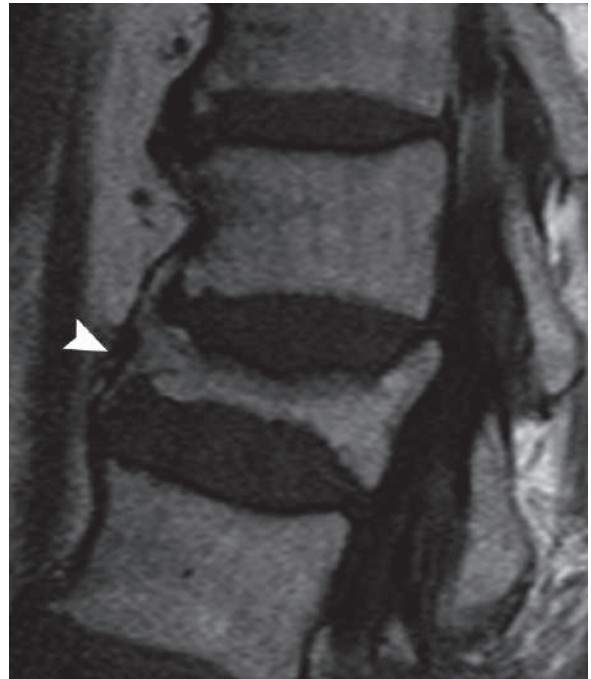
Sagittal thoracic vertebral MRI shows vertebra plana (arrowhead)
